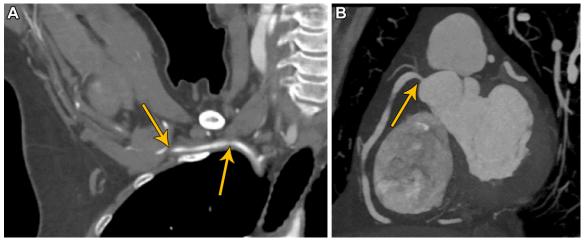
GCA in a 65-year-old woman with right hand numbness and upper extremity claudication. (A) Double- oblique right upper extremity CT angiogram shows circumferential wall thickening along the right subclavian and axillary arteries (arrows) with downstream occlusion. (B) Short-axis coronary CT angiogram shows moderate stenosis (arrow) of the RCA origin due to large-vessel vasculitis.
